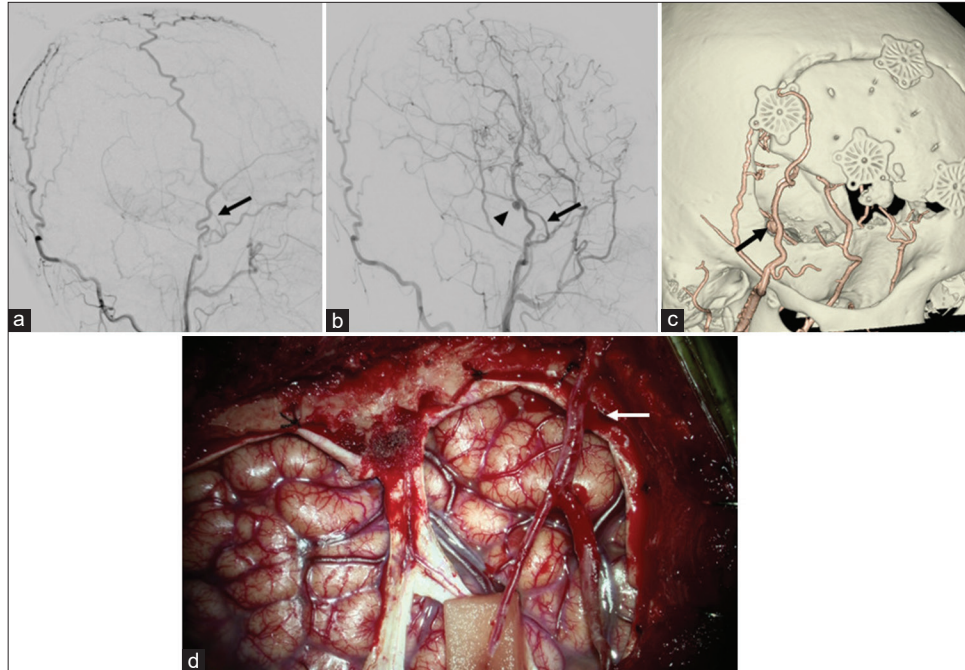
(a) Anterior-posterior angiography before revascularization surgery. (b) Lateral angiography of the right external carotid artery at 3 months after revascularization surgery. The angiogram shows a pseudoaneurysm (arrowheads, b) at the middle meningeal artery (arrows, a and b). The diameter of the middle meningeal artery at 6 months after the superficial temporal artery-to-middle cerebral artery (STA-MCA) bypass and encephalo-duro-myo-arterio-pericranio-synangiosis (EDMAPS) was larger than that before surgery. (c) Fusion image of computed tomography and right external carotid artery angiography. The pseudoaneurysm is located at the edge of the craniotomy (black arrow). (d) Intraoperative photo of STA-MCA bypass and EDMAPS. The arrow is location of pseudoaneurysm hereafter.
